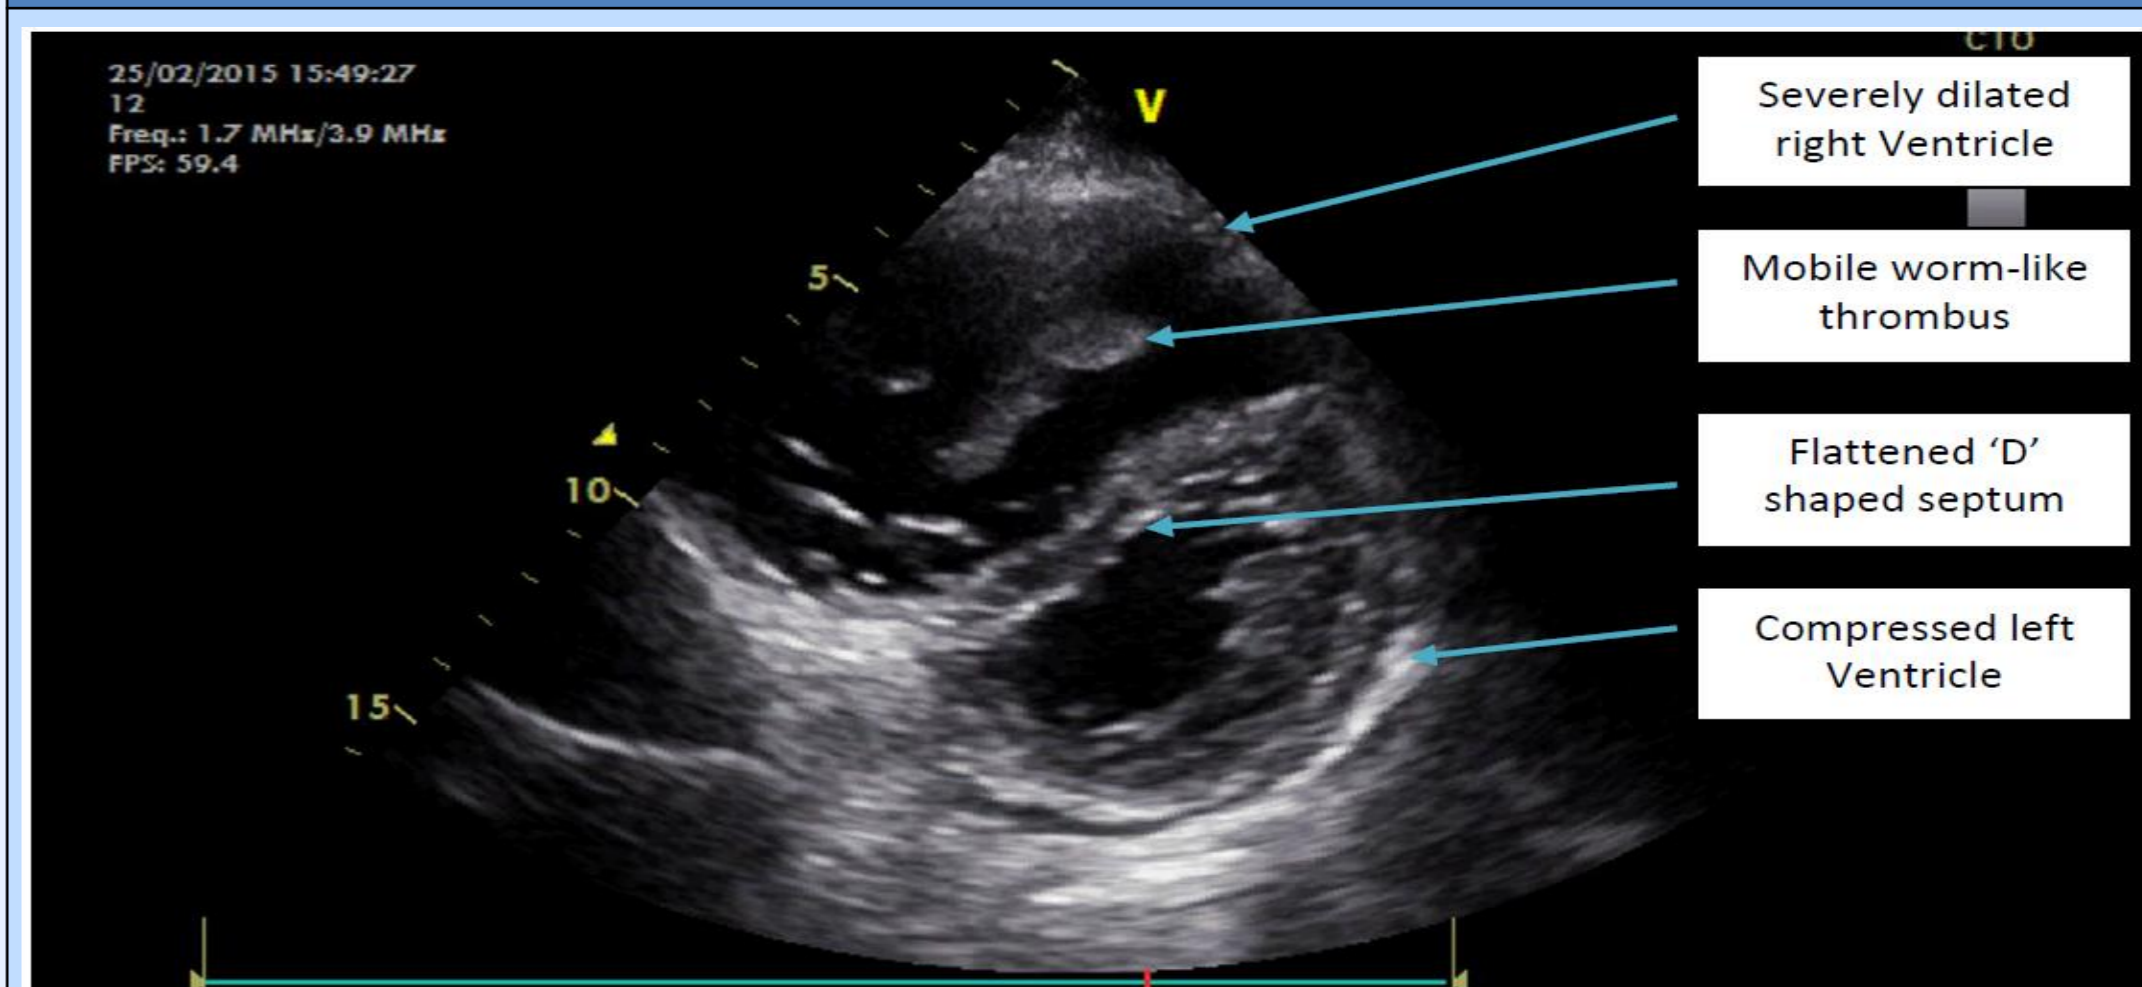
Trans-thoracic echocardiogram: Parasternal short-axis mid LV view showing dilated RV with flattened 'D' shaped LV and thrombotic material within the RV.
